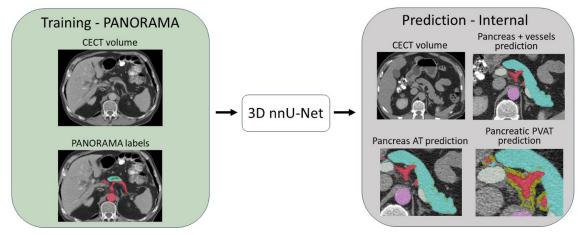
Framework for the proposed approach to segment pancreatic anatomy and predict PVAT. A 3D nnU-Net model was trained on the publicly available PANORAMA dataset (n = 1350) using a 5-fold cross validation. The trained model was then applied to an internal dataset (n = 606) consisting of contrast-enhanced CT scans (CECT). The perivascular region was obtained by dilating the predicted arteries (red). Adipose tissue (gold) in both the perivascular region and the pancreas parenchyma (light blue) was identified using a [-190, -30] Hounsfield unit (HU) range. AT - adipose tissue.
